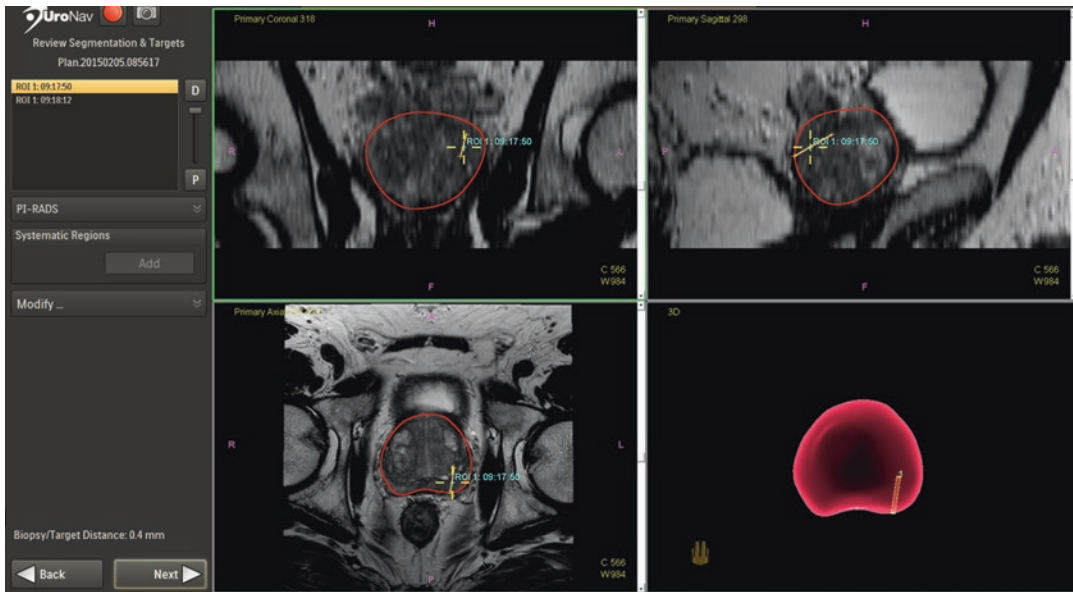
UroNav screen capture of imported T2-weighted images demonstrating MR prostate segmentation and region of interest for targeted biopsy
